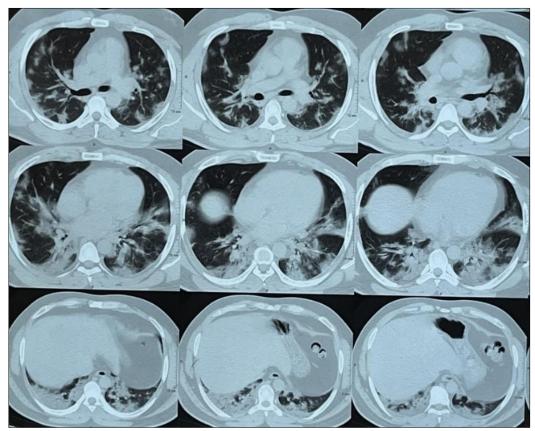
HRCT thorax showing bilateral GGOs and consolidations in upper, middle and lower lobes with crazy paving
